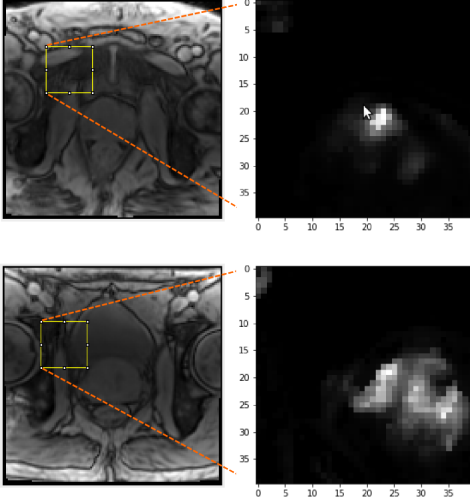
Top: T1-weighted Fast Low Angle Shot (left) and a K^{trans} image patch (right) showing a true positive. Bottom: T1-weighted Fast Low Angle Shot (left) and a K^{trans} image patch (right) showing a false positive.
